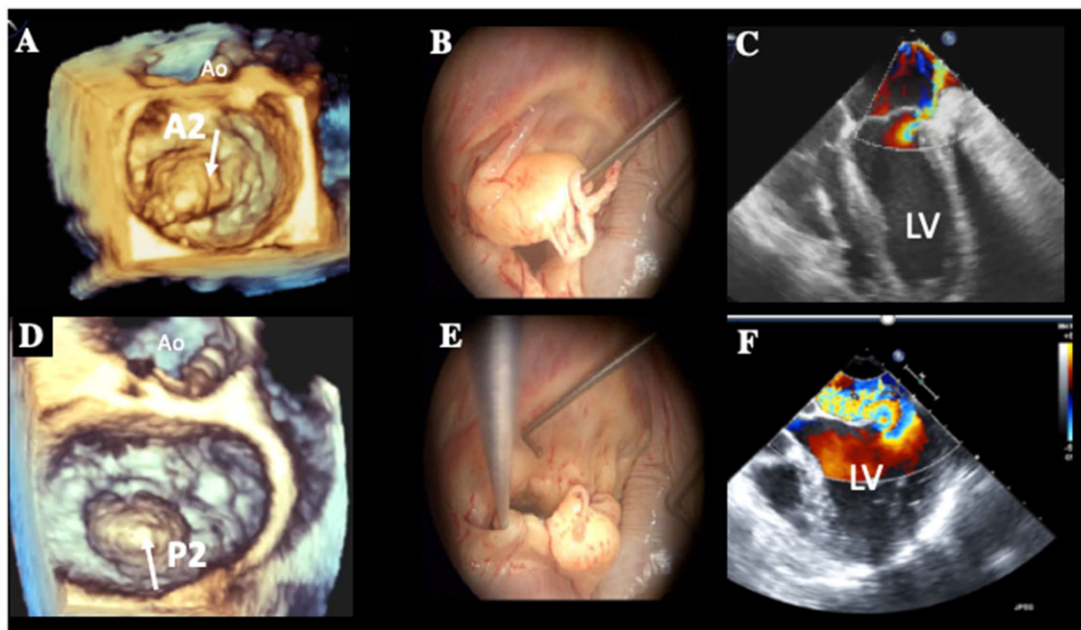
Examples of anterior (top panels) and posterior prolapses (bottom panels). (A) Flail of A2 (arrow) with (B) the corresponding intraoperative image and (C) the colour Doppler showing the direction of the jet towards the lateral wall of the left atrium. (D) Flail of P2 (arrow) with (E) the corresponding intraoperative image and (F) the colour Doppler showing the direction of the jet towards the interatrial septum.
